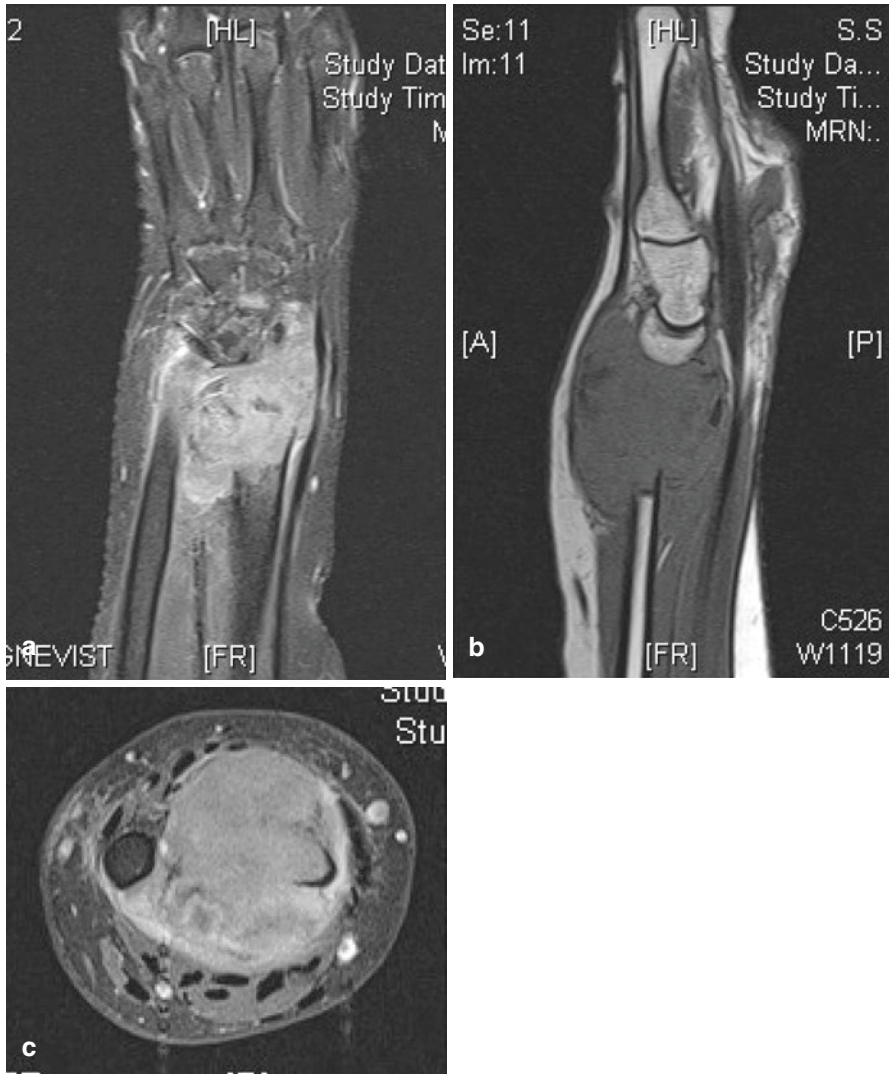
(a) Coronal T2-weighted fat-suppressed contrast-enhanced, (b) sagittal T1-weighted and (c) T2-weighted fat-suppressed contrast-enhanced MRI images of a grade 3 giant cell tumour of the distal radius. (d) En bloc resection of the tumour and reconstruction with an autograft fibular arthrodesis. (e) Anteroposterior plain radiograph of the reconstruction with autologous fibula supplemented with a spanning plate
